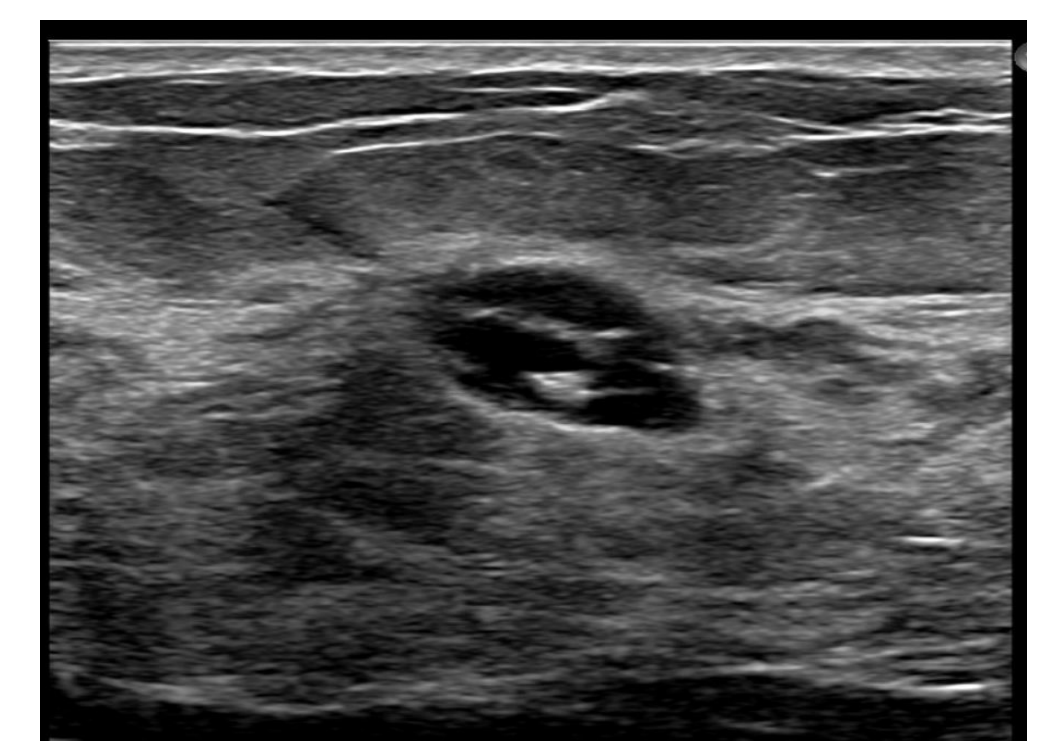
Ultrasound showed a 1.7 x 0.9 x 1.4 cm oval, hypoechoic mass with irregular margins in the left upper central breast at 12:00, 3cm from the nipple.
